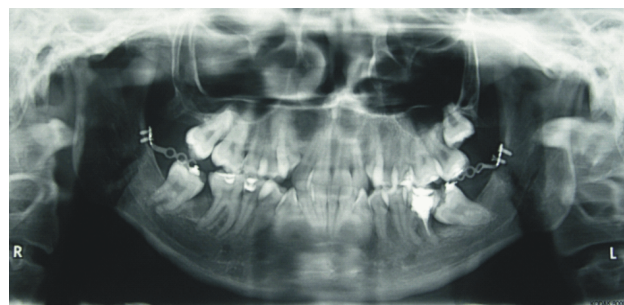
Panoramic X-ray during orthodontically assisted eruption of MM2.
